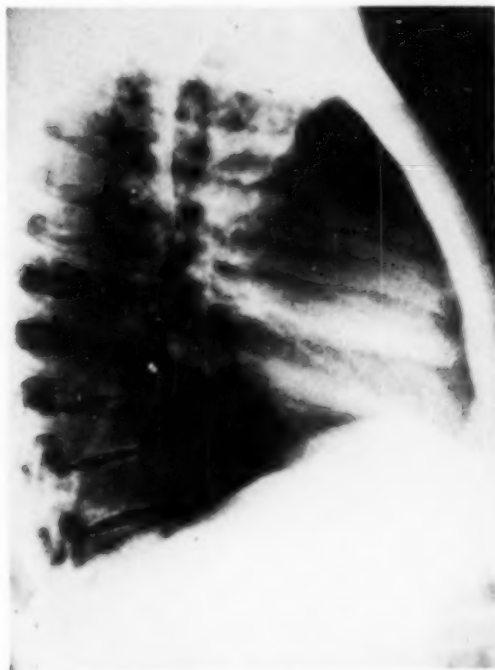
Case 1 (lateral roentgenogram)
